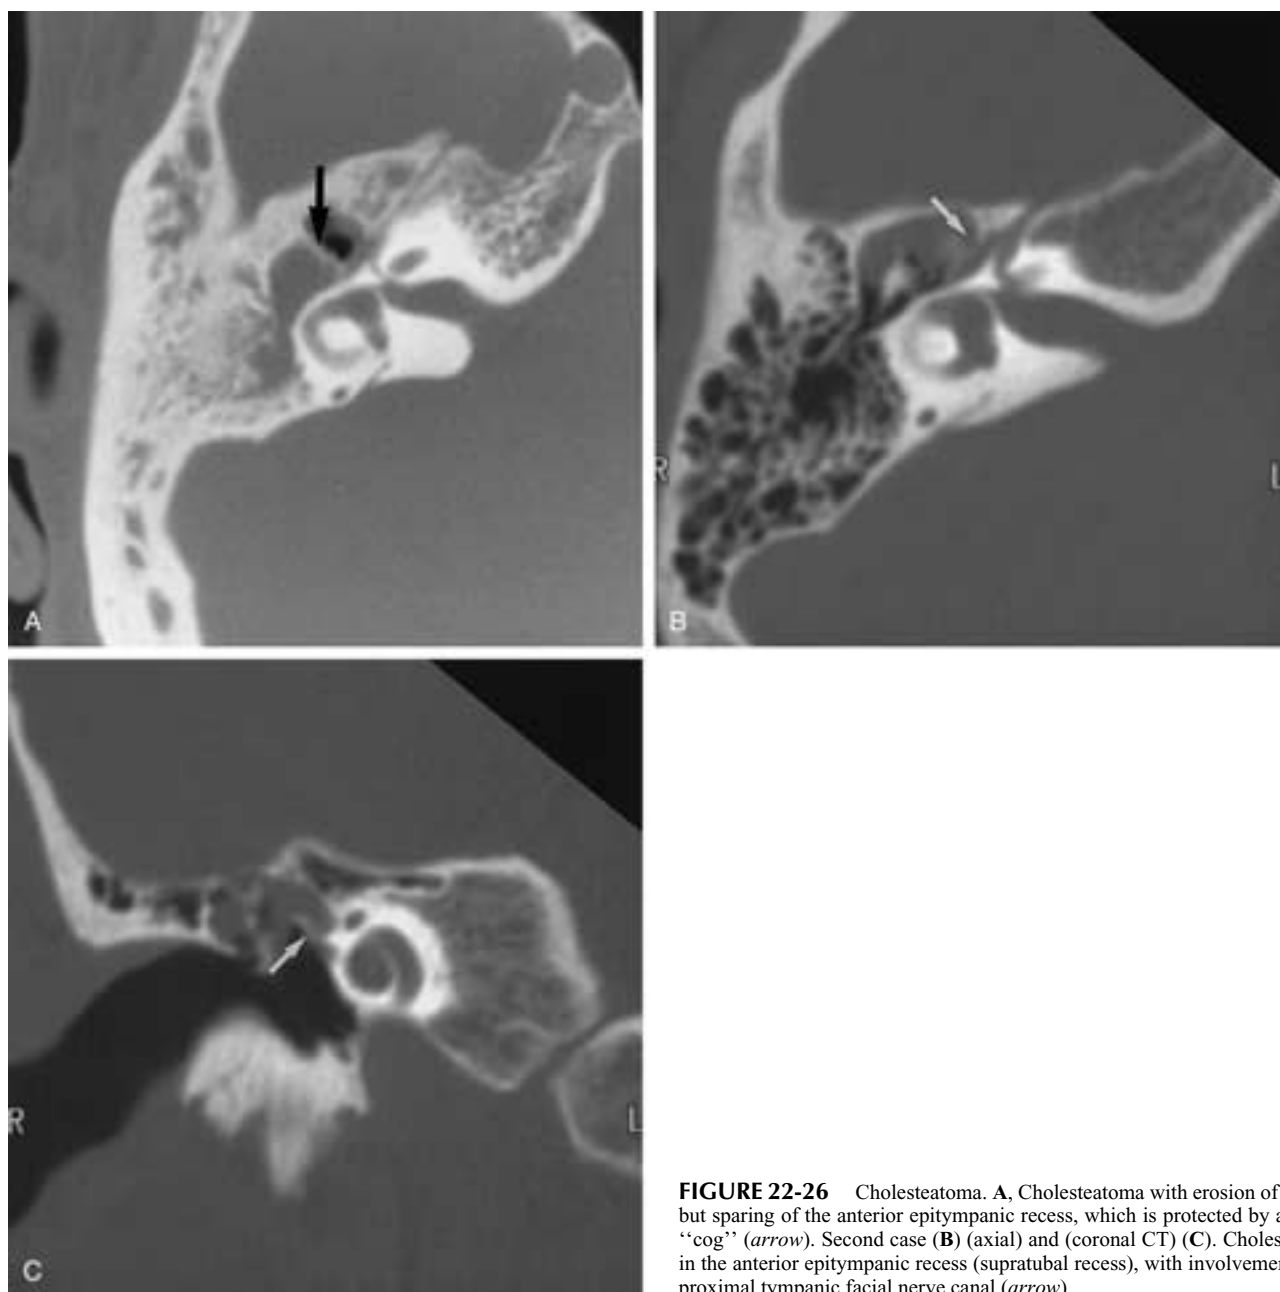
Cholesteatoma. A, Cholesteatoma with erosion of ossicles but sparing of the anterior epitympanic recess, which is protected by an intact “cog” (arrow). Second case (B) (axial) and (coronal CT) (C). Cholesteatoma in the anterior epitympanic recess (supratubal recess), with involvement of the proximal tympanic facial nerve canal (arrow).
